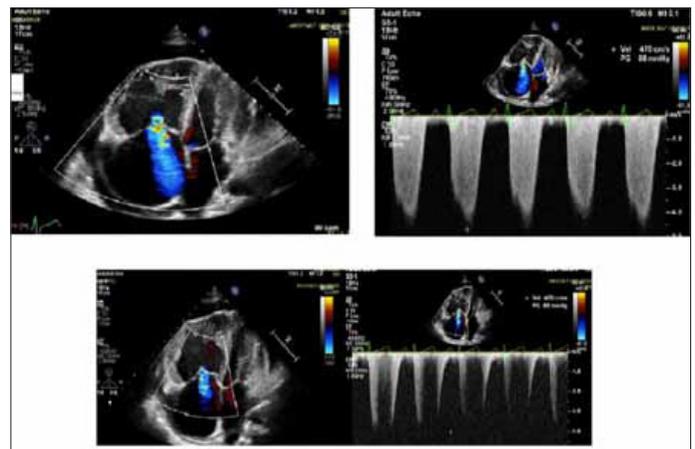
Comparative view of severe tricuspid insufficiency and PAP calculated over maximum TR velocity with the 2nd echocardiography performed after drug withdrawal and achievement of clinical euolemia.
